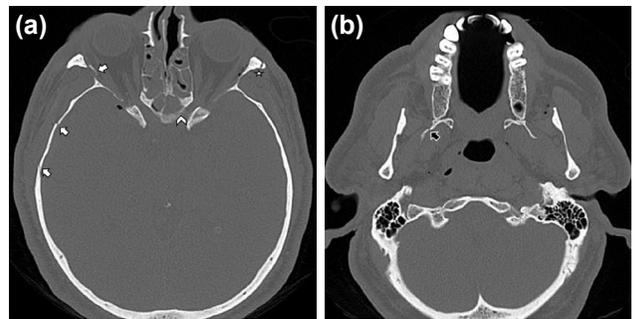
A 36-year-old man with sphenotemporal buttress fracture. Axial CT image (a) reveals a fracture of the right sphenotemporal buttress (arrows). The left zygoma is also fractured (asterisk). The fracture extends through the central skull base (a, arrowhead) and into the right pterygoid plates (b, arrow).
